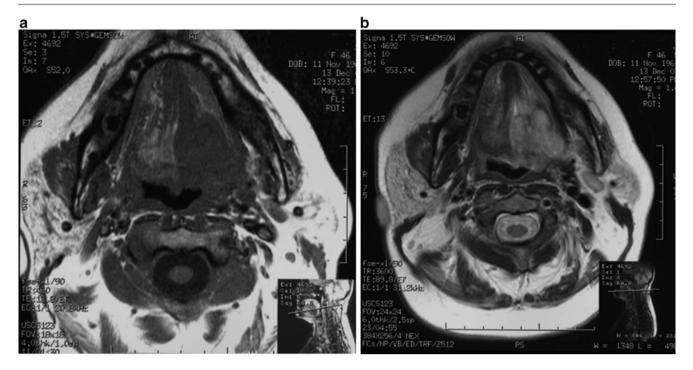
Squamous cell carcinoma of the tongue in a 48-year-old female patient. The MRI shows the lesion extending and occupying the right side of the tongue. T1 weighting (a) and T2 weighting (b)
